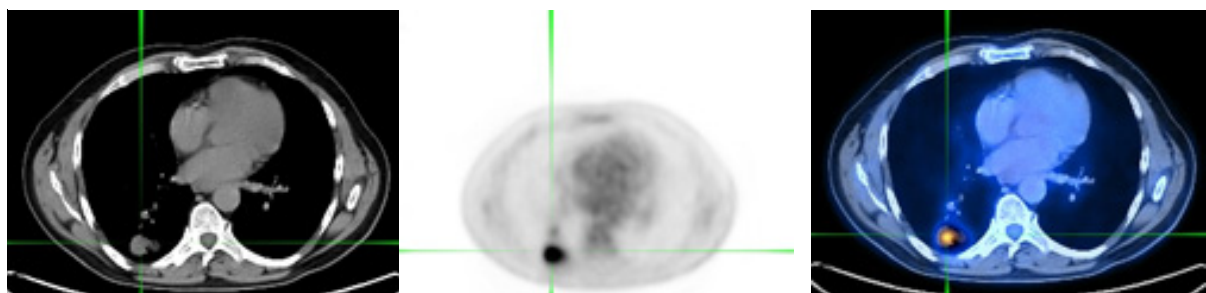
Transversal chest slices. Left) CT; Centre) PET; Right) PET-CT
